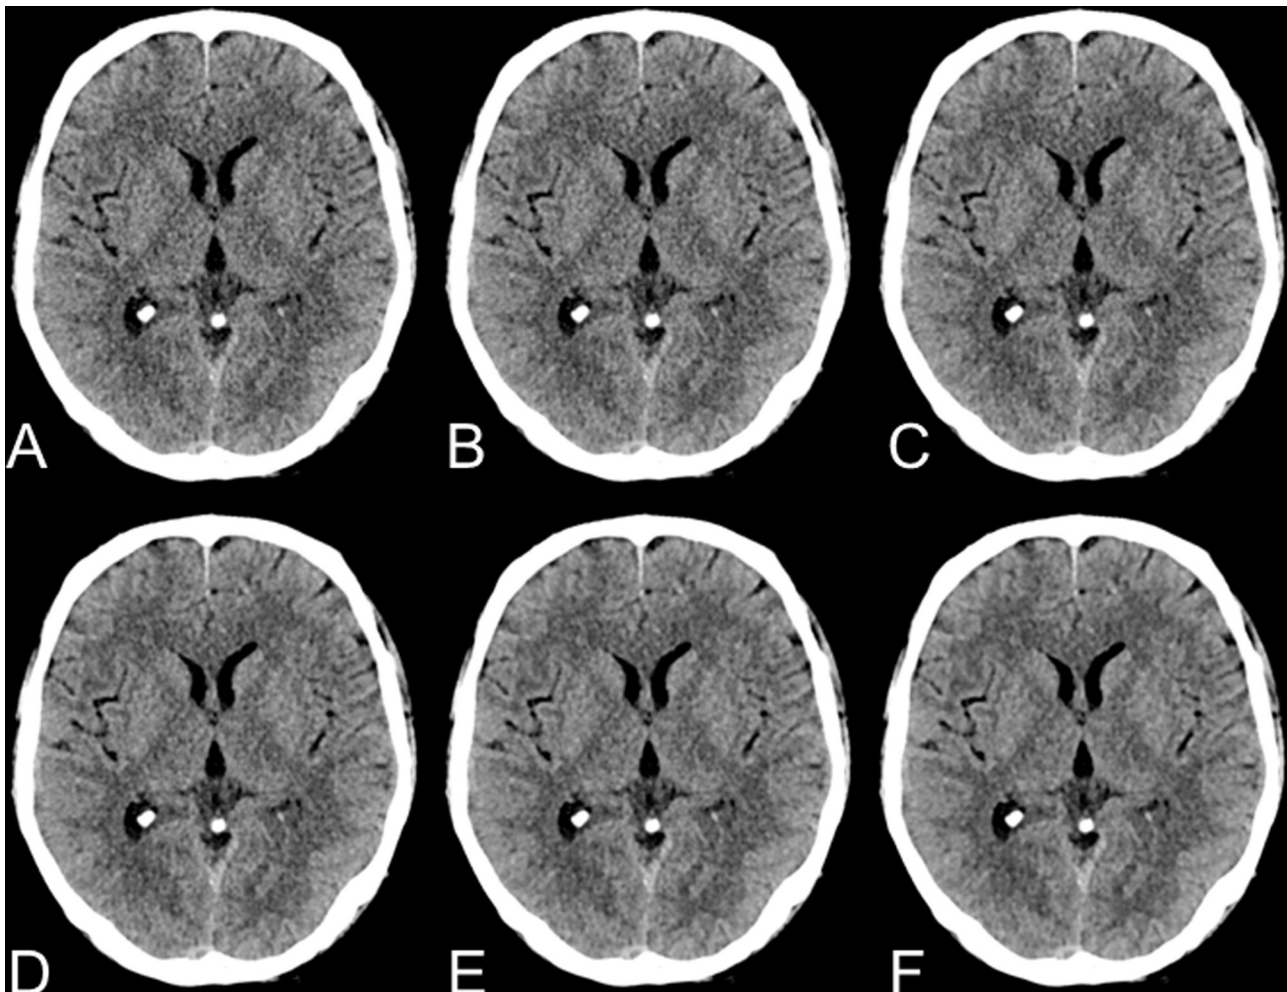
Cranial CT of a 51-year-old male patient after traumatic brain injury in spiral acquisition mode of a DSCT, using FBP and IR algorithm at 5 different IR strength levels: A = FBP, B = IR 1, C = IR 2, D = IR 3, E = IR 4, F = IR 5.
